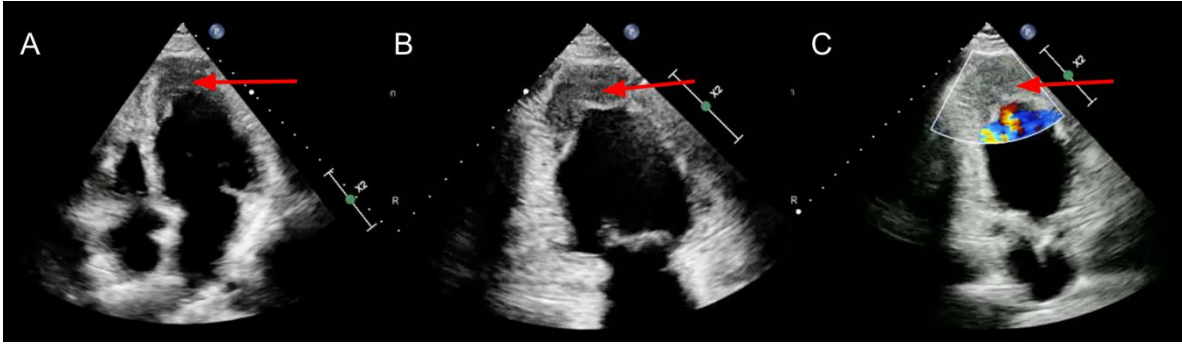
2-Dimensional Transthoracic Echocardiogram
